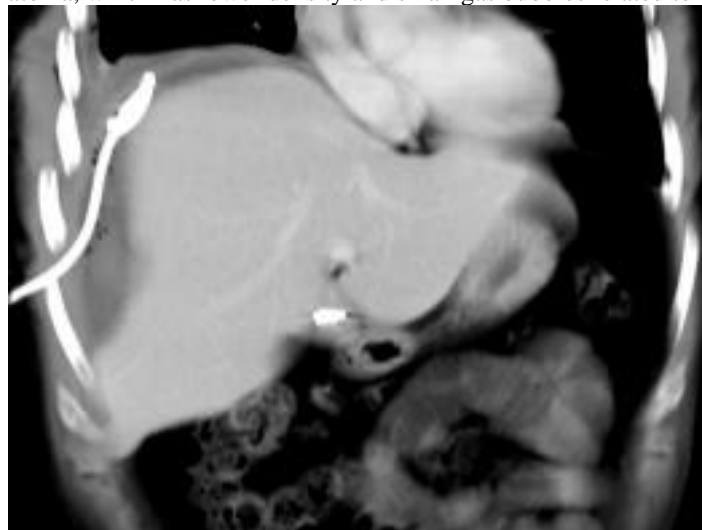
Abdominal CT scan, post-contrast phase, axial plane: drain well located inside the hematoma with partial reduction of the hematoma volume.
